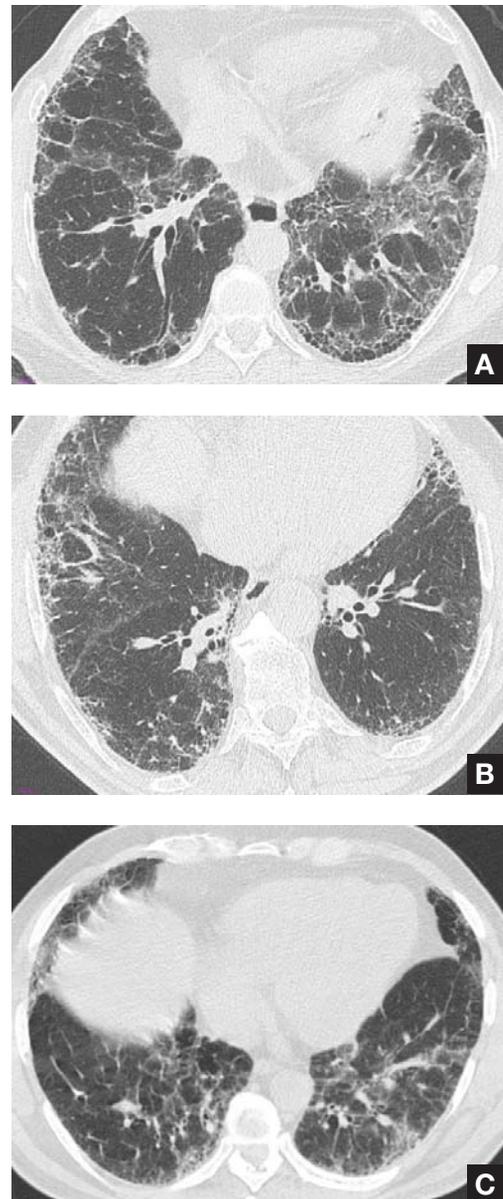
HRCT imaging showing UIP pattern.
